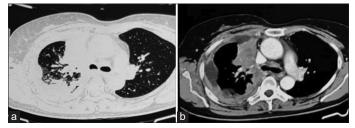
Sagittal view of computed tomography of the patient (a) Lung window (b) Mediastinal window
